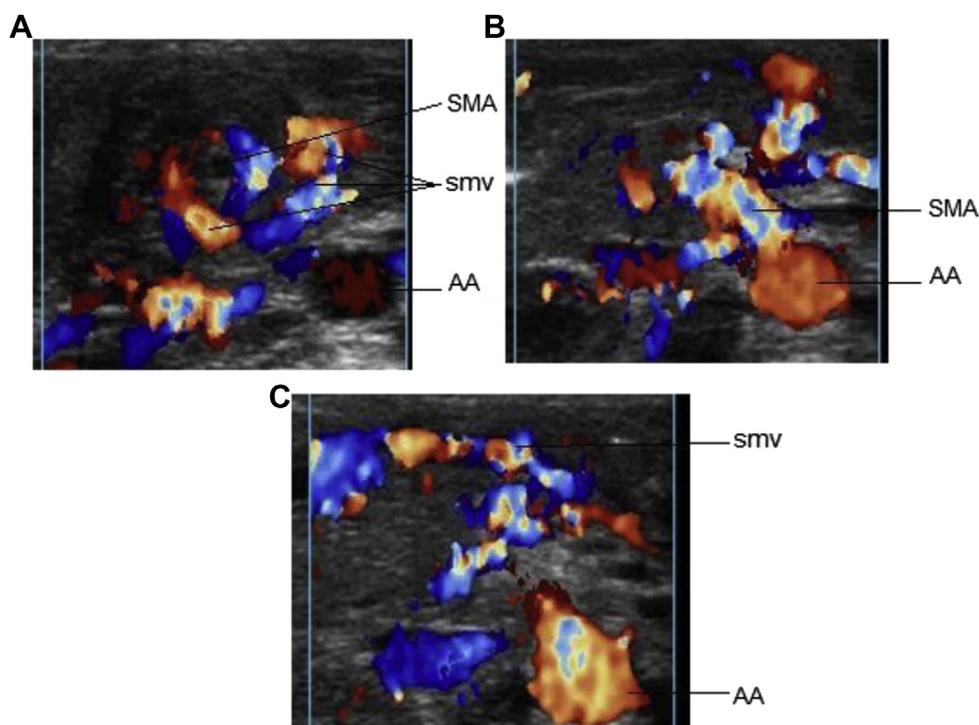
Color Doppler abdominal ultrasound with high frequency linear transducer: superior mesenteric artery (SMA) arises from abdominal aorta (AA) (B) and goes to the center of a round mass-like structure—the twisted mesentery. SMA turns around superior mesenteric vein (SMV) in a clockwise fashion (A) than follows its way toward the portal vein (C).
